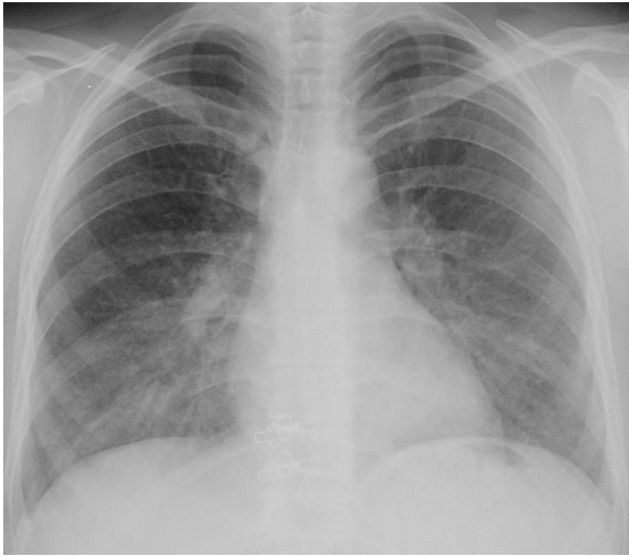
Chest x-ray in patient.
